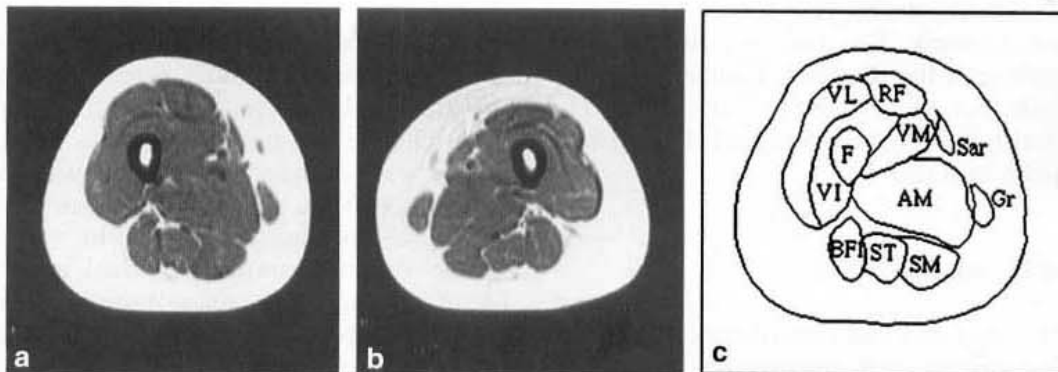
shows the representative MR images of the mid thigh of a (36 year-old female patient) of the operated (Fig. 1 b: left thigh) and non-operated (Fig. 1 a: right thigh). Decrease in the CSA of the QF in the operated limb is clearly shown compared to the non-operated limb.
